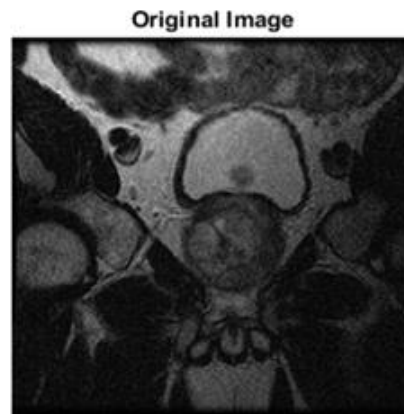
Original MRI image
